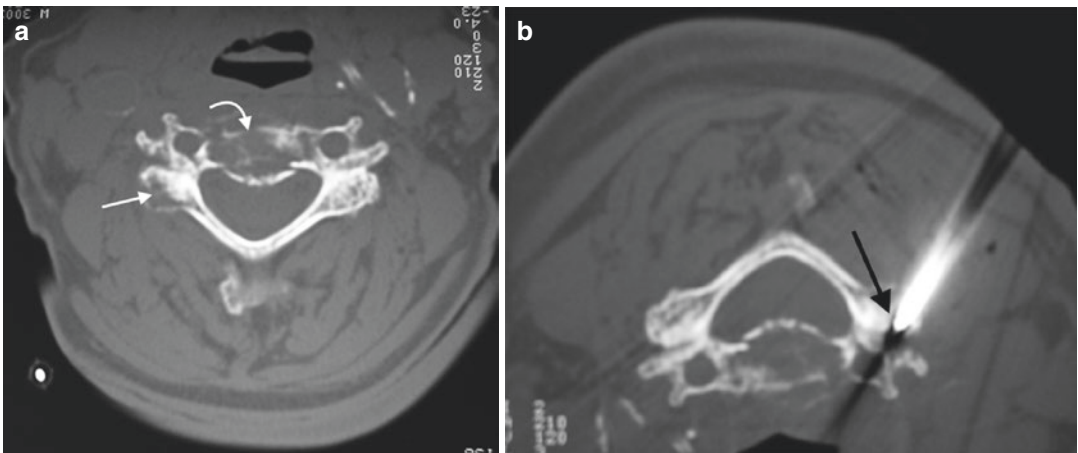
Axial CT image in bone window algorithm (a) shows lytic lesions within the vertebral body (*curved arrow*) and the right articular pillar (*arrow*). Axial CT
